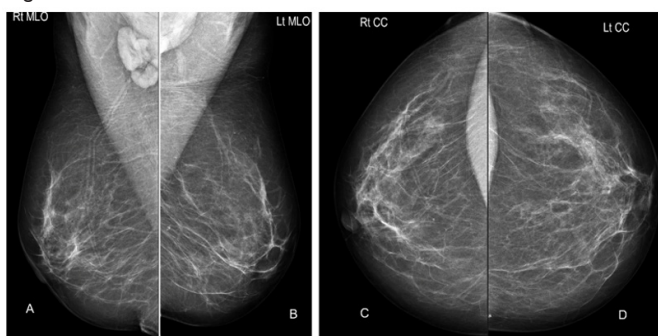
MLO (A,B) and CC (C,D) mammograms: bilateral pathologic axillary lymph nodes. There were no suspicious findings in the breast parenchyma at mammography, nor any change from previous mammograms. Clinical breast examination and breast ultrasound revealed no abnormalities in the breasts.
